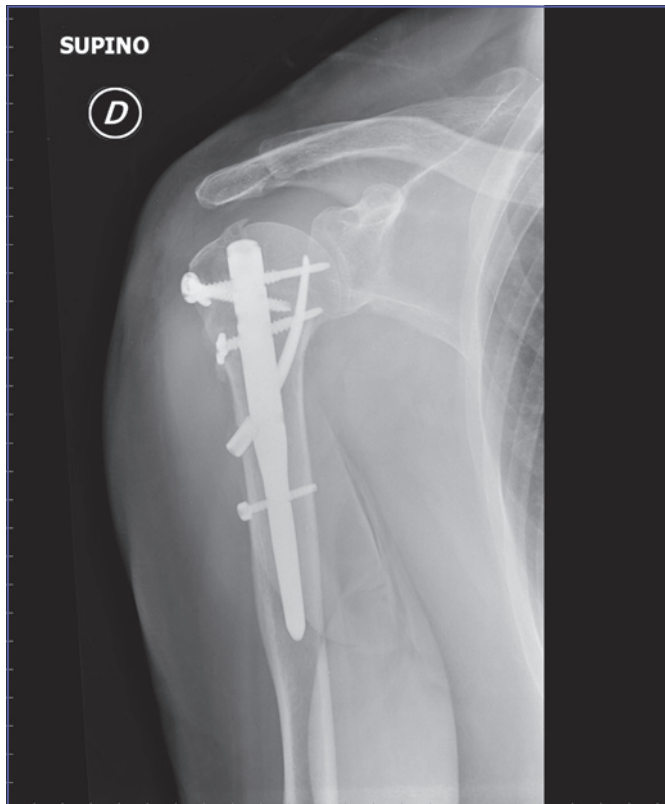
Same patient as Figure 1, postoperative X-ray.
